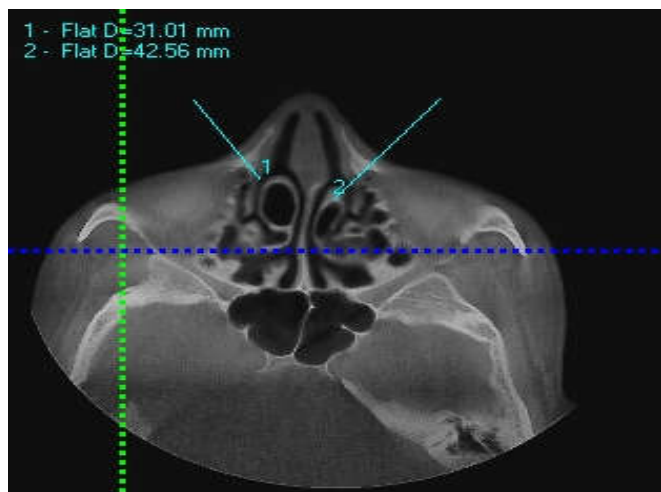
Axial section of CBCT showing choncha-bullosa
